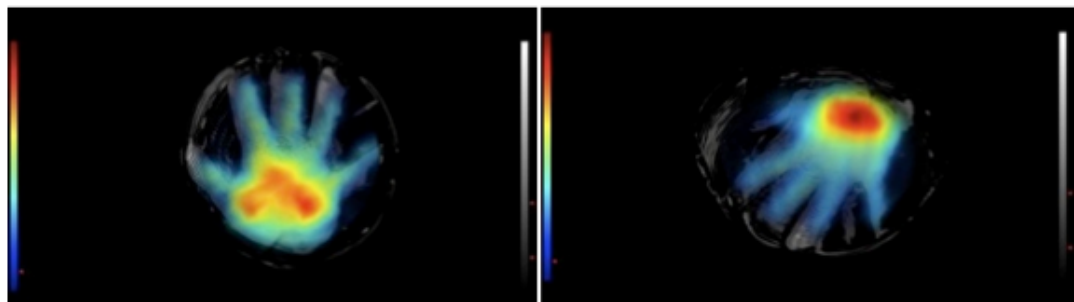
Image merger of 3D ultrasound and EIM scans; palm view (left); back/wrist view (right).
